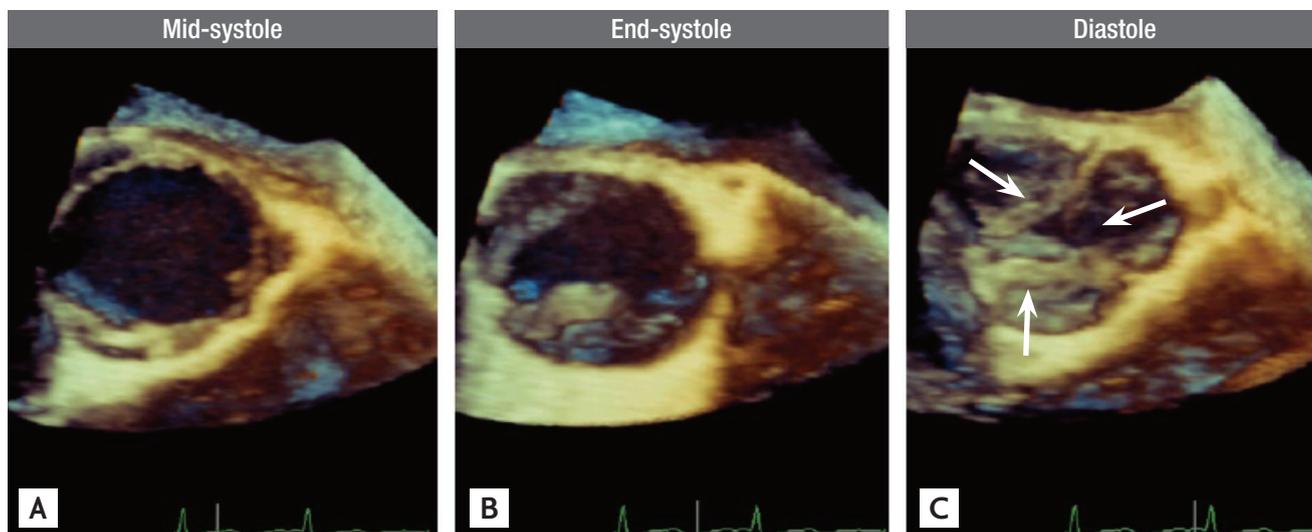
Three-dimensional transesophageal echocardiography images of an aortic valve with severe aortic valve regurgitation. (A) Panel shows the valve in mid systole, (B) panel in end systole, and (C) panel in diastole. Arrows indicate a large regurgitant orifice viewed from the ascending aorta.
